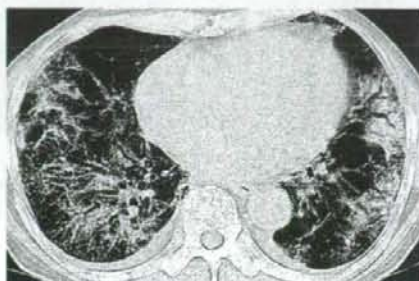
Type C : other type, mixed GGO and consolidation. A 69-year-old man was given a diagnosis of MTX-P. CT shows GGO intermingled with multiple foci of consolidation.
